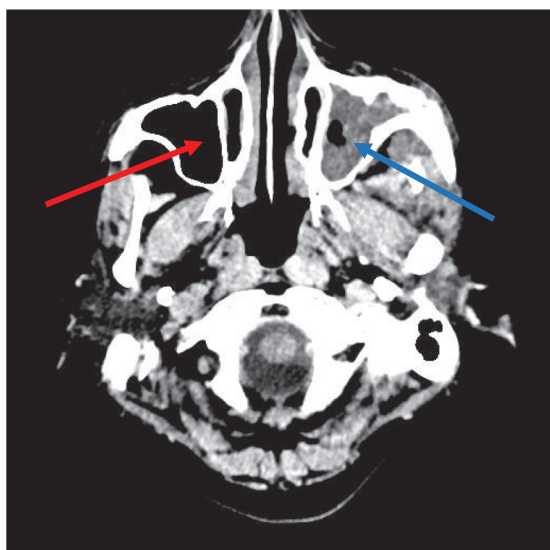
Contrast-enhanced CT scan. Collection in the left maxillary sinus (blue arrow). Note the normal right maxillary sinus (red arrow).
